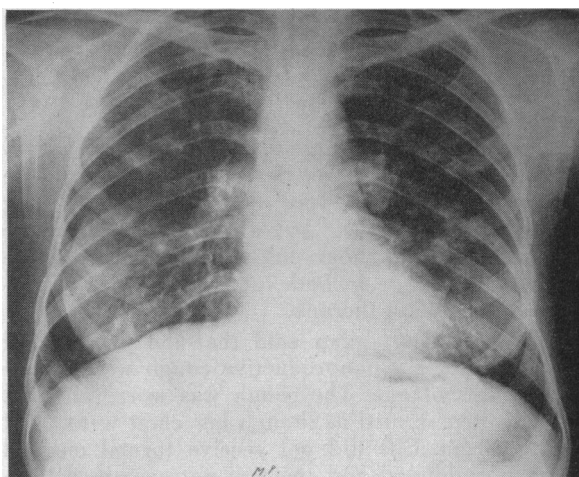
X-ray film of chest taken September 25, 1957, showing extension and accentuation of the infiltrative shadows in both lung fields as compared with April 13, 1955.
